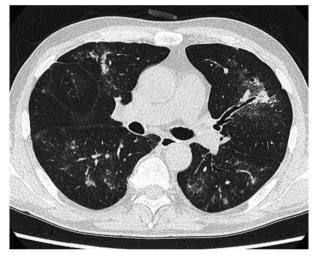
Chest CT scan on Day 28. There is marked improvement of the bilateral diffuse ground-glass opacities.
